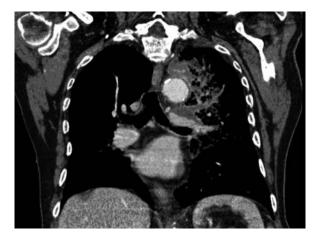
Chest CT, coronal plane. Pulmonary infiltrate with pleural evolvement. Infarctioned area shows an advanced fibrotic retraction in which a rich vascularization and consequent cystic bronchiectasis are evident.
